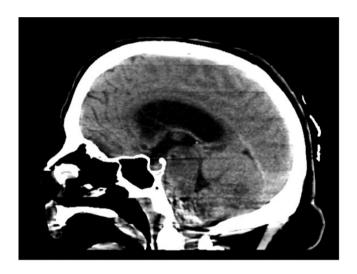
Noncontrast computed tomography (CT) brain sagittal view with obliterated fourth ventricle with ventricular dilatation above the tentorium suggestive of obstructive hydrocephalus. Loss of normal gray-white matter differentiation of cerebellum suggestive of diffuse bilateral infarction
